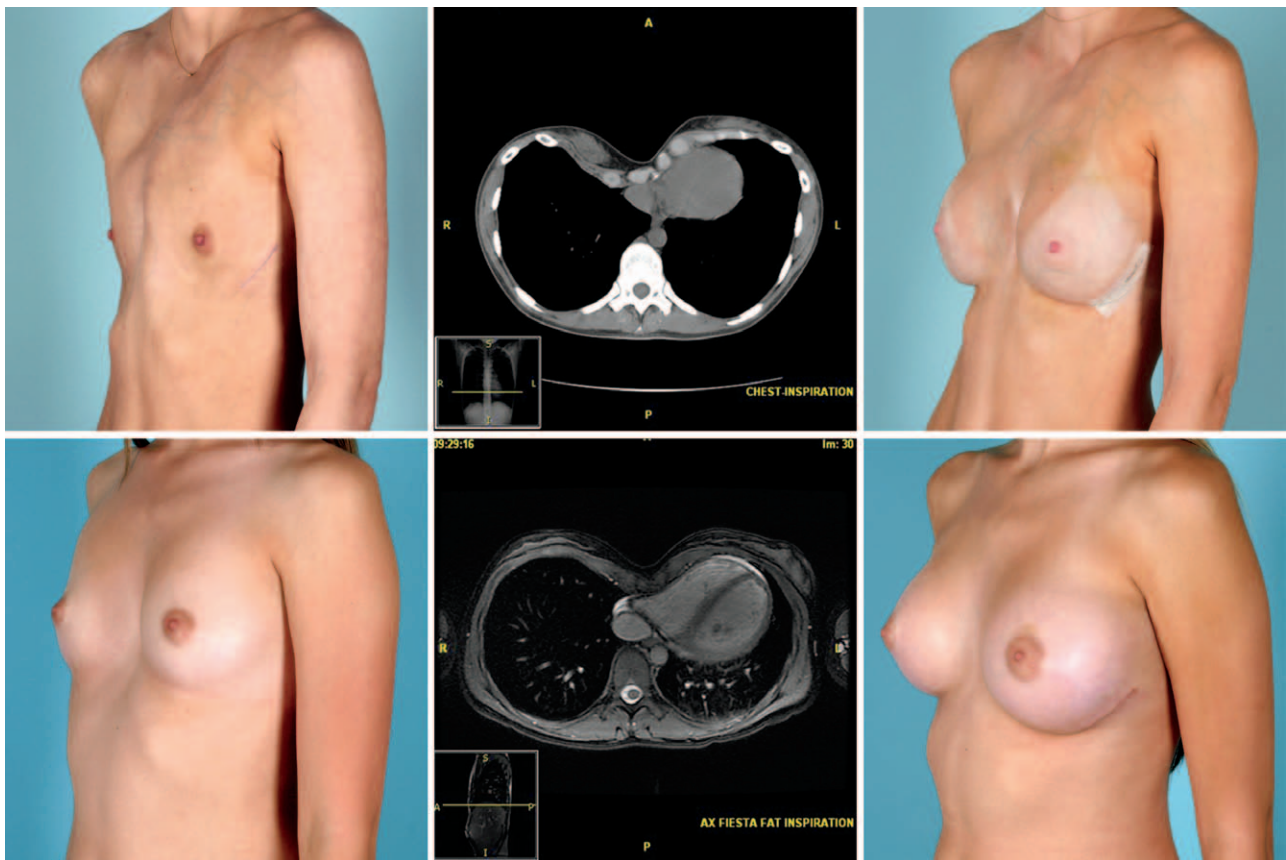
Preoperative clinical photographs (left), computed tomographic scan (above, center) and magnetic resonance image (below, center), and (right) postoperative clinical photographs of (above) a 23-year-old woman with severe pectus excavatum deformity and a severity index of 12.5 and (below) an 18-year-old woman with severe pectus excavatum and a severity index of 7.3.
